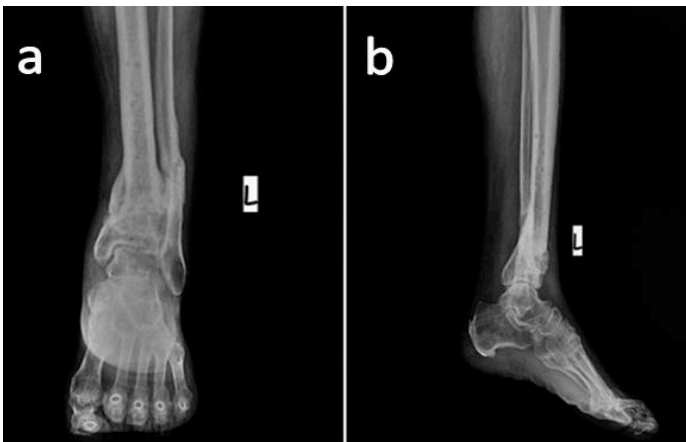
Final period radiographs of patient number 6 who had open fracture. a, varus deformity; b, tibia distal diaphyseal metaphyseal flexion
